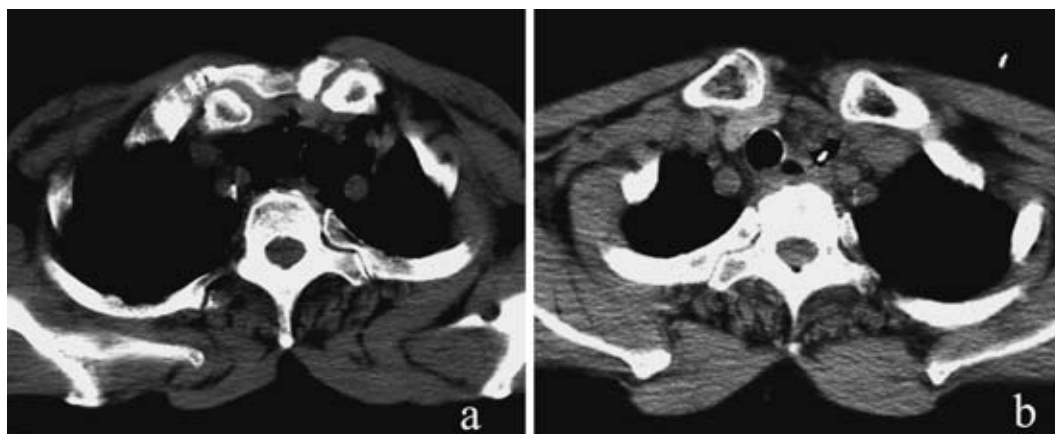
a: A CT scan after perforation revealed marked air accumulation in the neck and mediastinum, especially notable around the esophagus and trachea, b: Mediastinal drainage resulted in a significant reduction of air in the mediastinum.
